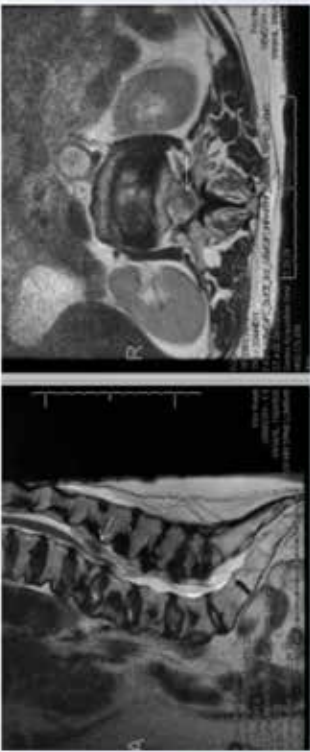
MRI Lumbar Spine T2 sequence in both sagittal (LEFT) and transverse (RIGHT) sections showing the location of the epidural hematoma.
